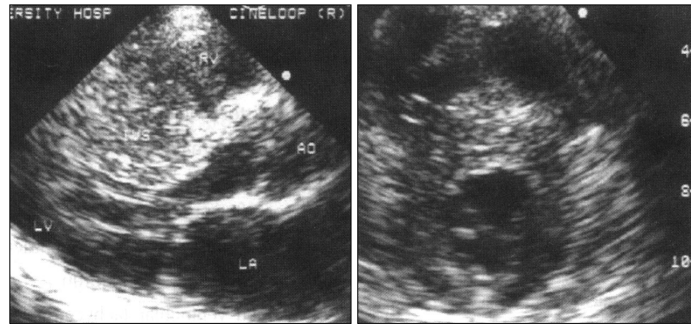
Left parasternal long and short axis echocardiograms show asymmetrical septal hypertrophy and speckling echoes in hypertrophic cardiomyopathy.
